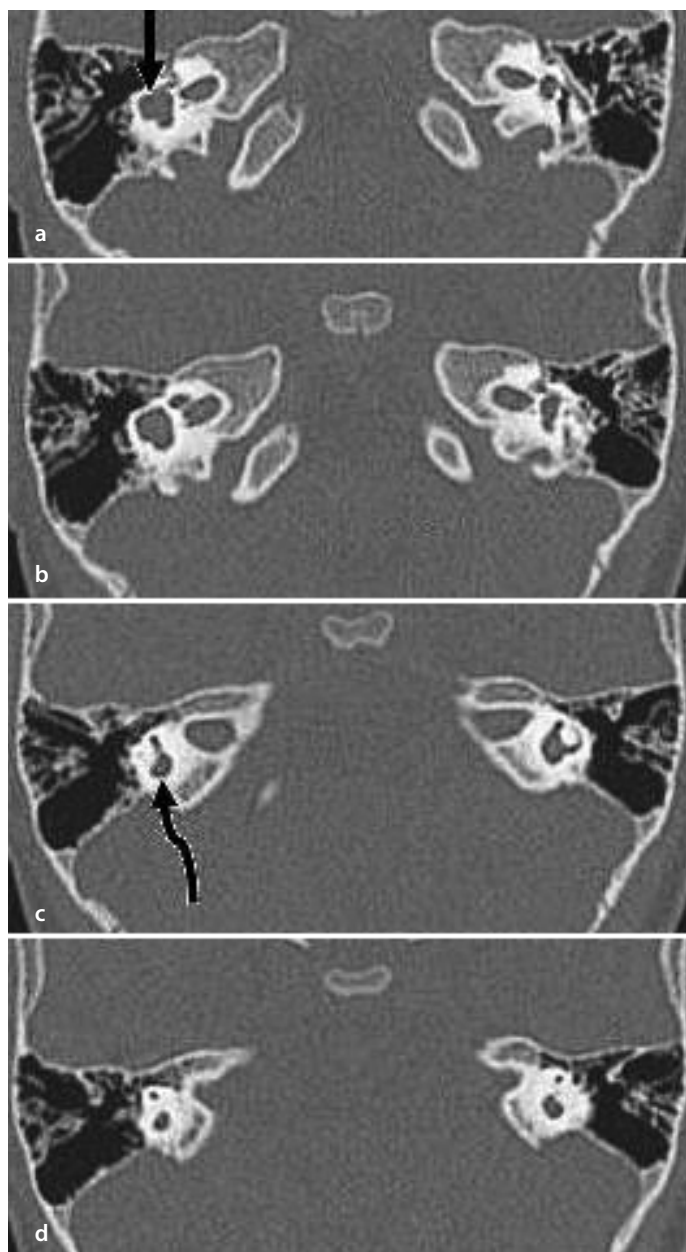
a-d. Consecutive temporal bone CT images from the caudal to cranial areas show complete fusion of the vestibule and LSC (straight arrow) on the right side. Both absence of the PSC and posterior limb dilatation of the SSC (curved arrow) are also shown
